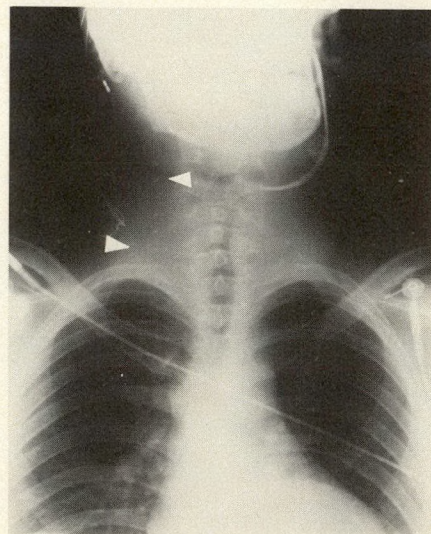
Intraoperative roentgenogram of neck and chest (Jan. 23, 1978) made after shunt tubing was cut. Upper end of distal tubing is seen 10 cm above clavicle (higher arrow). New ventriculoperitoneal shunt is in situ (lower arrow).
